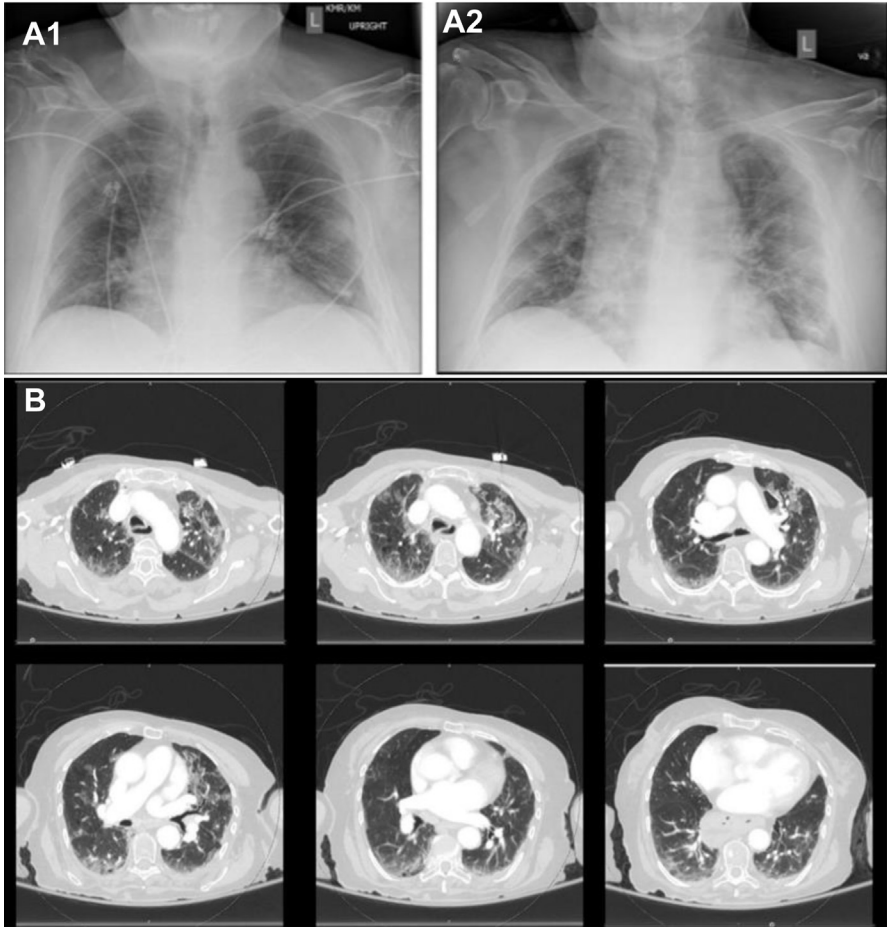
Radiological Identification. (A) [1] CXR at admission, and [2] at 36 hours, shows progression of pulmonary findings. (B) CT scan demonstrates mild-moderate ground-glass opacities favoring the periphery. (Modified from Shea H, Holinski J, Benedetti R, et al. Mechanical Ventilation for COVID-19. <https://courses.edx.org/courses/course-v1:HarvardX+COV19x+1T2020/course/>. Published April 13, 2020. Accessed November 30, 2020.)
